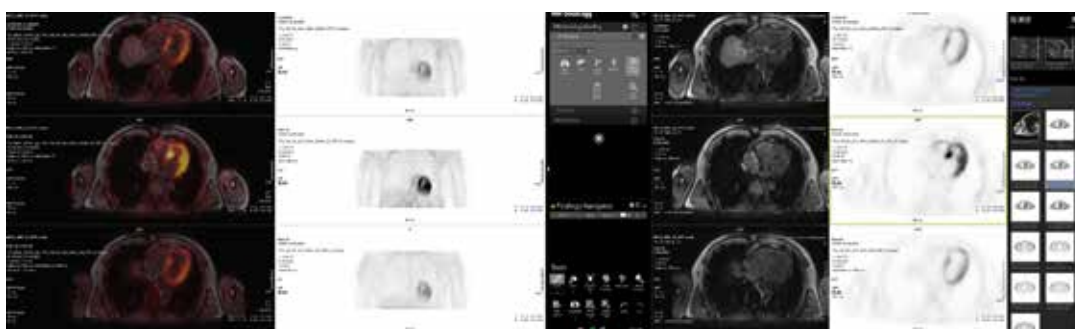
Cardiac PET-MRI imaging in one subject 30 days following hypoxic exposure (upper panel), last day of hypoxia under 9,5% fraction of inspired oxygen (centred panel), and at baseline (lower panel).
